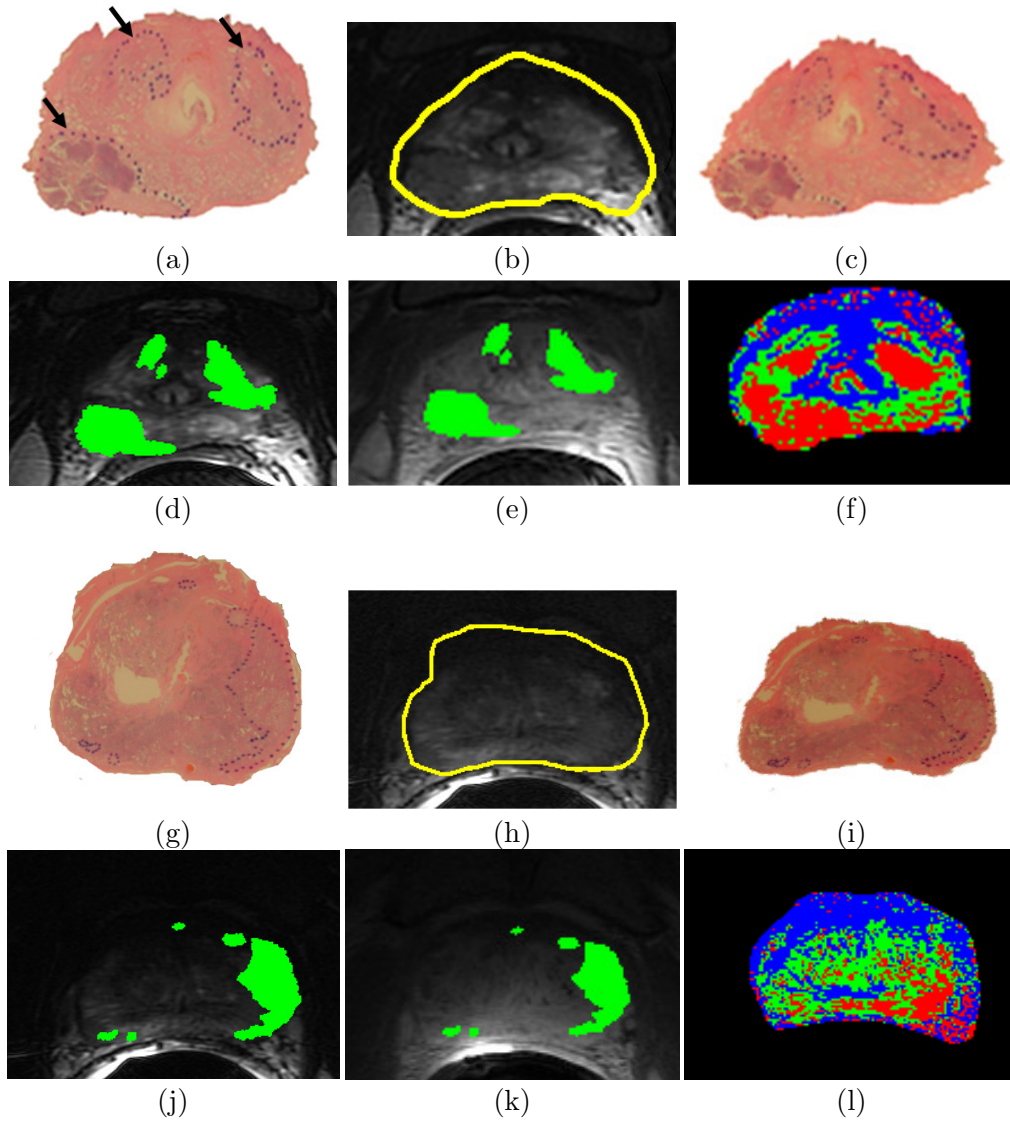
Registration of WMH to 3T in vivo T2-w MRI and DCE-MRI of the prostate with cancer. (a) WMH with cancer extent delineated (dotted lines) is registered to (b) corresponding T2-w MRI using COLLINARUS to generate (c) transformed WMH in spatial alignment with the prostate in (b). (d) T2-w MRI with the cancer extent mapped from (c) superimposed in green. (e) DCE-MRI registered with (d) by an affine transformation, shown with cancer extent (green) mapped from (d) T2-w MRI. (f) The commonly used 3TP representation of the DCE data in (e), which provides an independent estimate of CaP extent, demonstrates that the cancer extent mapped by registration is accurate. (g)-(l) Similar results are demonstrated for a different set of multimodal prostate images from another study.
